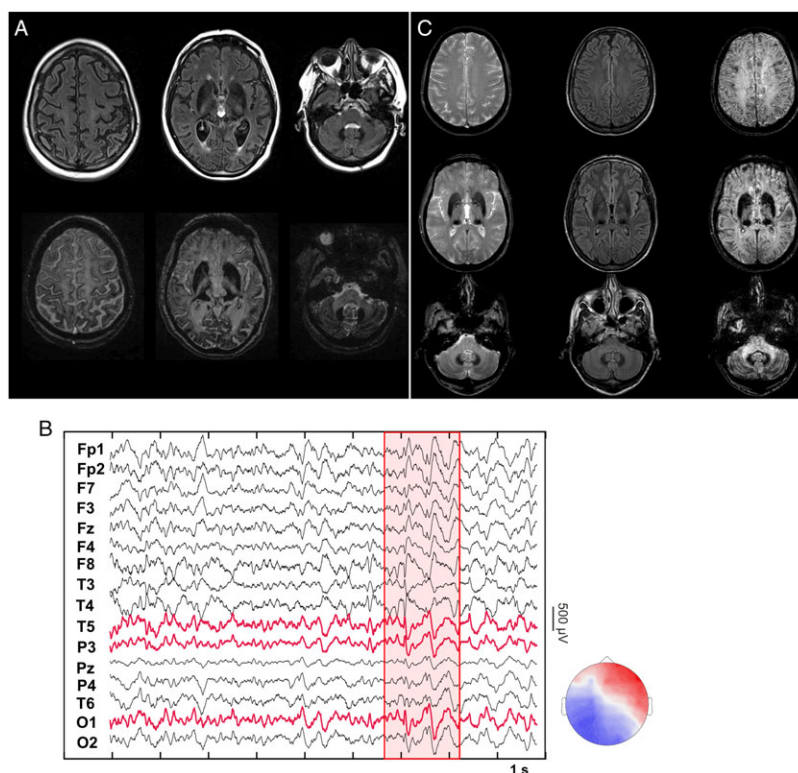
(A) Brain MRI of Patient 1, 3 years after the case, was reported by Melgari *et al.* in 2015. FLAIR and SWI sequences are depicted in the upper and lower panel: iron is massively deposited in the cortex, within the basal ganglia, especially in the dorsomedial thalamus, and in the dentate and cerebellar cortices. (B) EEG recording of Patient 1 (high-pass filter: 1 Hz; low-pass filter: 70 Hz; average reference). On the right lower panel: topographic 2D voltage-map at the negative peak of the left temporo-parieto-occipital (T5, O1 > P3) epileptiform discharges. (C) Brain MRI of Patient 2 at last imaging follow-up (2012): gradient echo (left), FLAIR (middle) and especially BOLD (right) show iron deposition similar to Patient 1.
